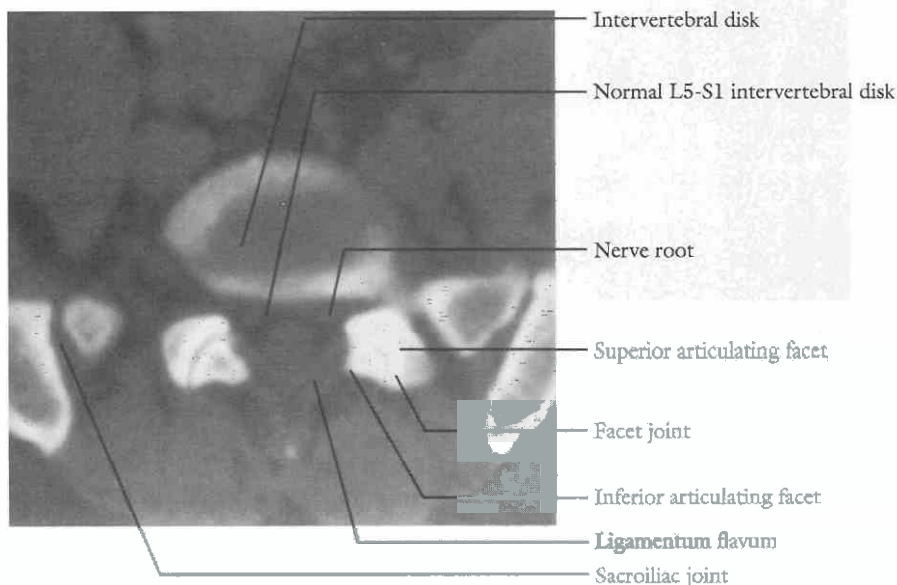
Axial CT scan through the intervertebral disk space of L5-S1, demonstrating the flat, slightly concave border of the disk posteriorly, a normal finding. The posterior aspect of the disk spaces is concave in remainder of spinal column.
